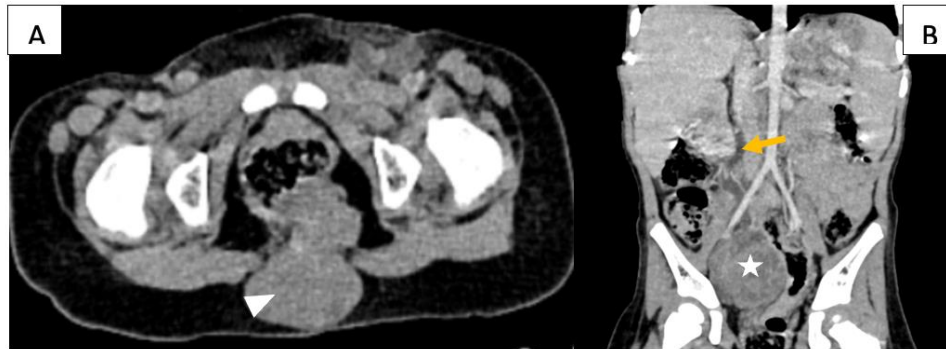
Initial CT – Extent and Complications. Axial (A) and Coronal (B) contrast-enhanced CT image demonstrating the presacral mass (arrowhead) and the regional lymphadenopathy (asterisk) causing compression of the right iliac ureter with resultant moderate hydronephrosis (arrow)
